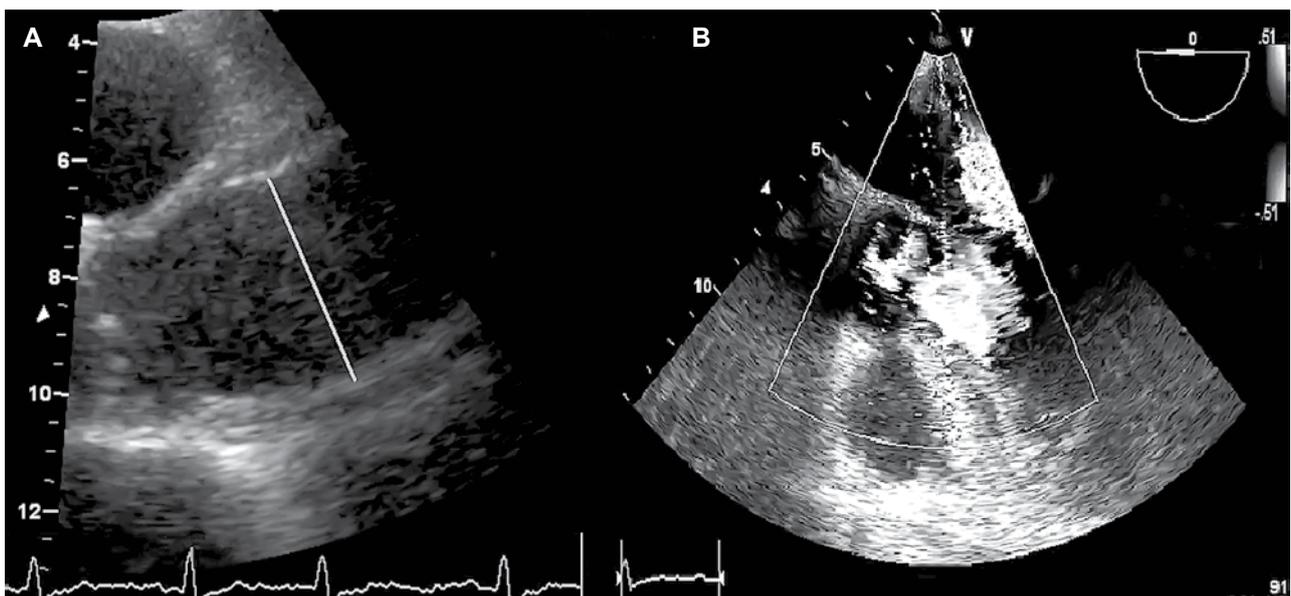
A) Transthoracic echocardiographic image showing the ascending aorta dilated at 4.6 cm (gray line), with circumferential thickening of the aortic wall indicative of aortitis. B) Transesophageal image showing severe aortic regurgitation.
